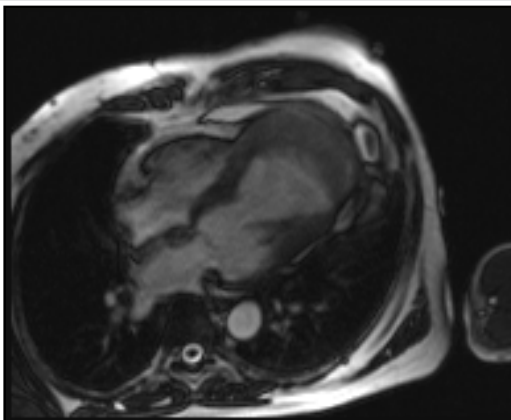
A and B: 2D Echo showing large LV aneurysm with organized clot C and D: Cardiac MRI in coronal and coaxial views showing large LV aneurysm with clot.
